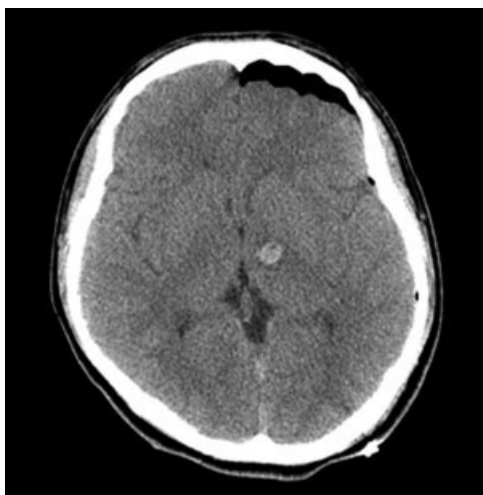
A brain CT of patient III:4, performed immediately after surgery, shows small high density lesion in the left thalamus.
